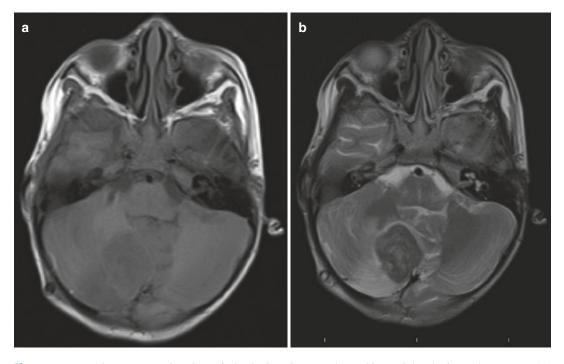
Magnetic resonance imaging of the brain showing a lesion in the right cerebellar hemisphere. It is well marginated and hypointense in T1-weighted images (a), hypointense on T2-weighted images (b). Post-contrast
